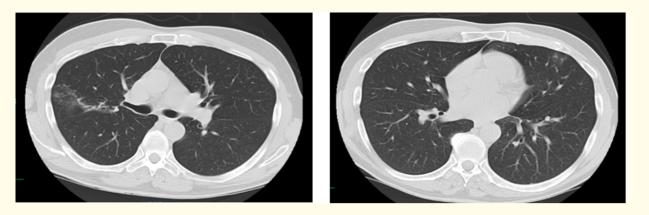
Computed tomography scan two months later showing marked improvement.
